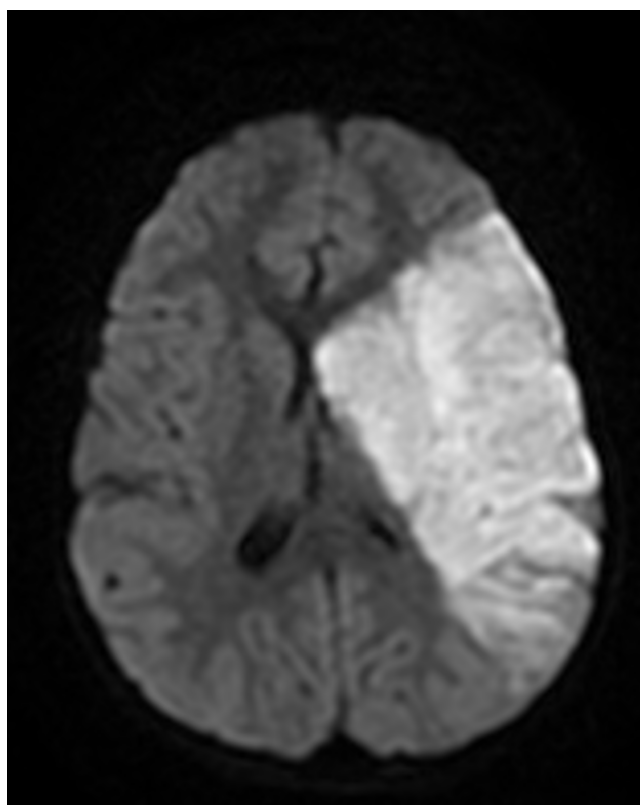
MRI of the brain showing hypersignal diffusion in the territory of the left sylvian artery in favour of an ischemic stroke.
